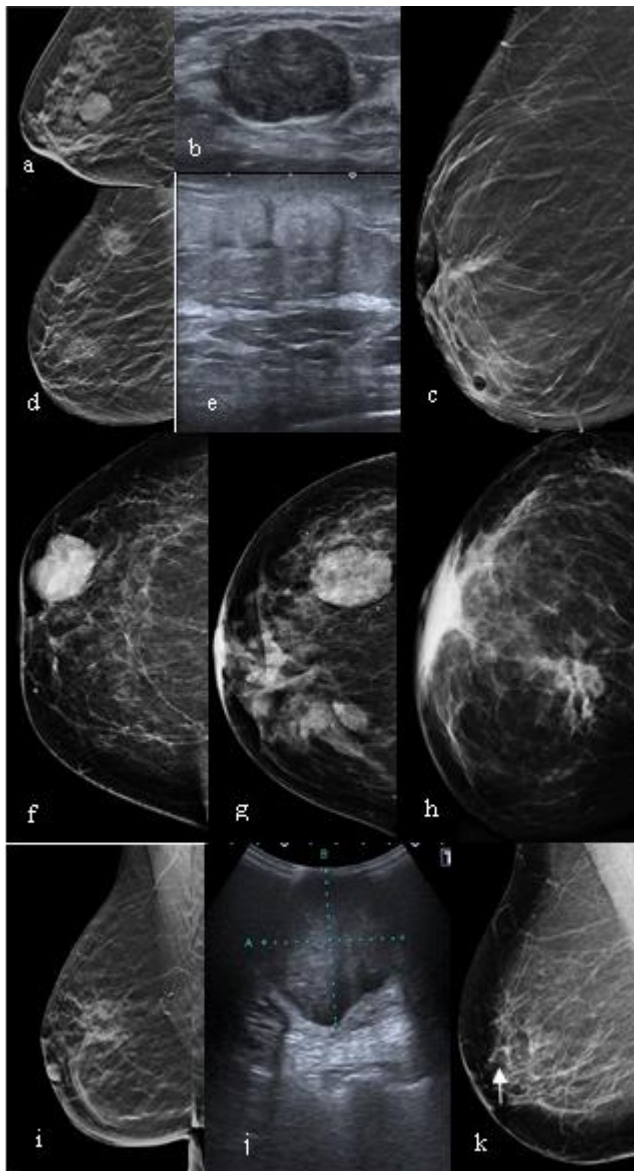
The imaging spectrum of disease seen in this study population. (a) Mammogram (RCC) and (b) ultrasound views of a biopsy confirmed fibroadenoma. (c) Mammogram (RMLO) of a patient with an oil cyst. (d) Mammogram (RMLO) and (e) ultrasound views of fat necrosis post mild trauma to the breast. (f) Mammogram (RCC) of a patient with biopsy confirmed malignant phyllodes. (g) Mammogram (RCC) of a patient with biopsy confirmed mucinous carcinoma of the breast. (h) Mammogram (RCC) of a patient with biopsy confirmed B-cell lymphoma of the breast. (i) Mammogram (RMLO) and (j) ultrasound of a patient with a biopsy confirmed invasive carcinoma. (k) Mammogram (RCC) of a patient with biopsy confirmed DCIS
